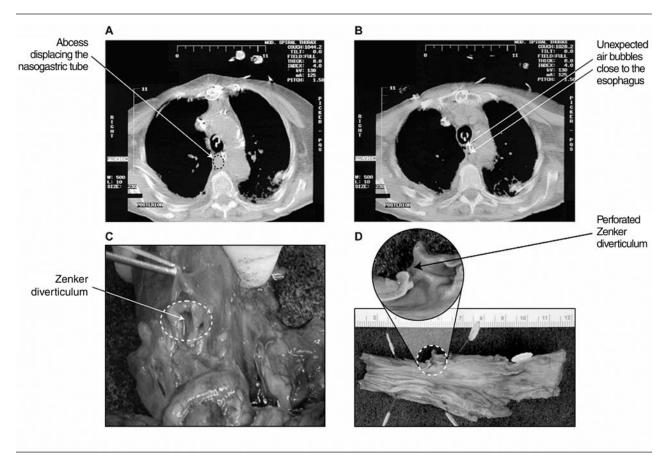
An 82-yr-old woman who died from septic shock after cardiac surgery. A) On computed tomography there was an abcess displacing the nasogastric tube. B) In addition there were some air bubbles close to the esophagus. C) From an external view, the autopsy showed the presence of an unexpected perforated Zenker diverticulum. D) Longitudunal internal view of the esophagus. The perforated Zenker diverticulum can be seen. It was perforated presumably by the transesophageal echocardiography probe either intraoperatively or postoperatively. Courtesy of Dr. Patricia Ugolini and Dr. Tack Ki Leung.
